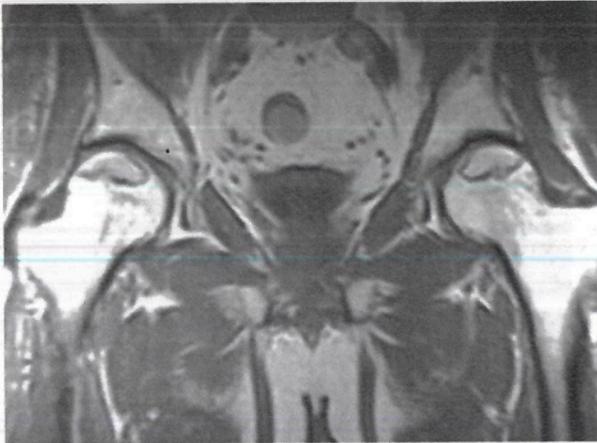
Coronal T1 Weighted MRI Scan of a patient with bilateral ON of the femoral head (Source: Medical University Publishing House, Craiova)
